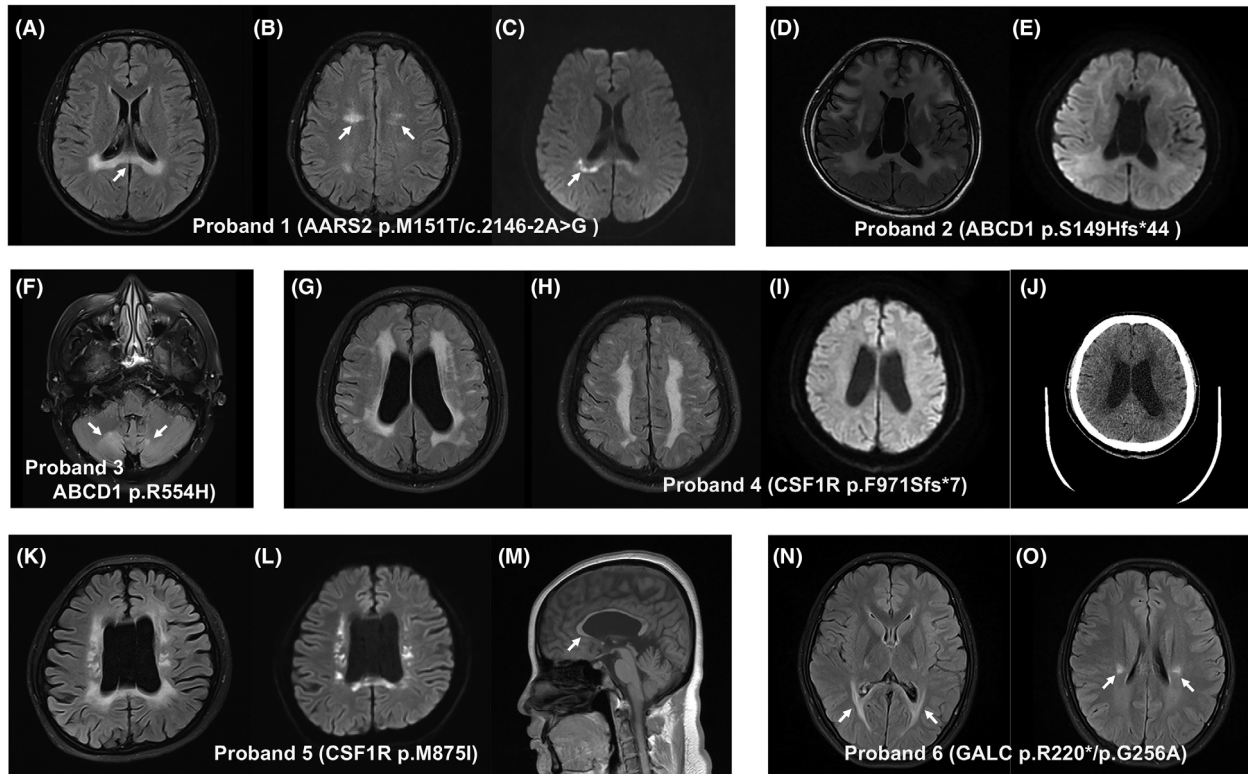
Brain magnetic resonance imaging (MRI) and computerized tomography (CT) findings in patients with genetic leukodystrophies. Hyperintensities in the body of the corpus callosum (A, arrow) and periventricular white matter (B, arrows) on T2 FLAIR images, and restricted diffusion on diffusion-weighted MR images (C, arrow), were observed in the patient (*proband 1*) with AARS2 mutations. (D) Axial T2 FLAIR images in the patient (*proband 2*) with ABCD1 p.S149Hfs*44 mutation show hyperintense signal changes involving not only the periventricular white matter and corpus callosum, but also internal and external capsules. (E) There was no restricted diffusion detected on diffusion-weighted MR images of the same patient. (F) Axial T2 FLAIR MR images showing nonspecific hyperintensities of the white matter in bilateral cerebellar hemispheres (arrows) in the patient (*proband 3*) with ABCD1 p.R554H mutation. (G and H) Axial T2 FLAIR MR images in the patient (*proband 4*) with CSF1R p.F971Sfs*7 mutation show hyperintensities in the periventricular and deep subcortical white matter. There was no restricted diffusion observed on diffusion-weighted MR images of the same patient (I). (J) Axial noncontrast brain CT of the same patient demonstrated no calcification. Ventricular enlargement and corpus callosal atrophy (M, arrow), with hyperintensities in periventricular white matter on T2 FLAIR images (K) and restricted diffusion on diffusion-weighted MR images (L), are observed in the patient (*proband 5*) with CSF1R p.M875I mutation. (N and O) Axial T2 FLAIR MR images in the patient (*proband 6*) with GALC mutations show involvement of the corticospinal tracts and periventricular white matter (arrows).
